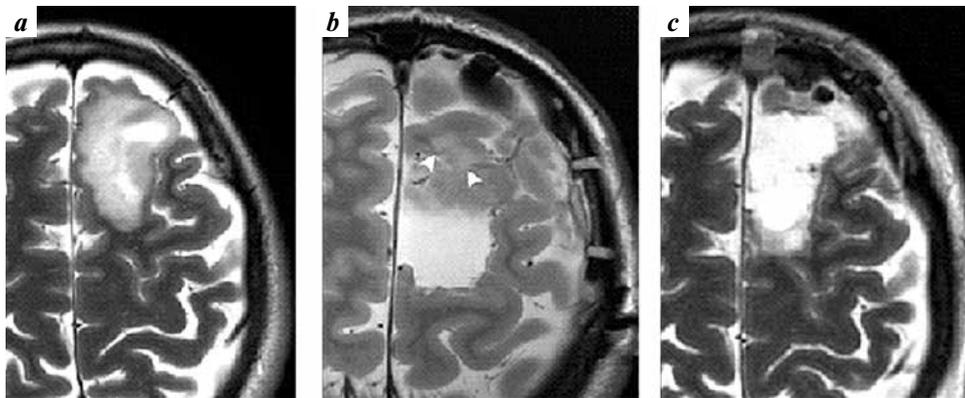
Brain MRI (Patient 7). Axial T2 non-contrast images: a – preoperative scan, frontal lobe tumor in premotor area; b – intraoperative MRI, residual tumor in anterior aspect of resection cavity (arrowheads); c – postoperative MRI with no signs of tumor after additional resection
